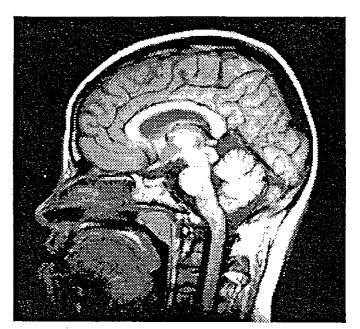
Midsagittal magnetic resonance images in Down syndrome (left) and Williams syndrome (right). Note the relative callosal circularity and cerebral hypofrontality of the Down syndrome image.
